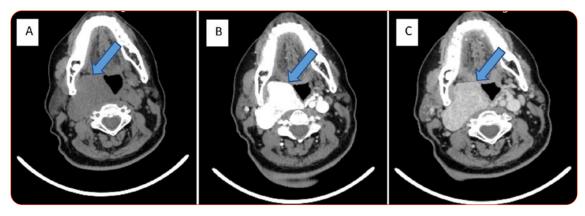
Axial CT images demonstrating: the pre-contrast (A), arterial- (B) and venous phase (C) of the CBT.
